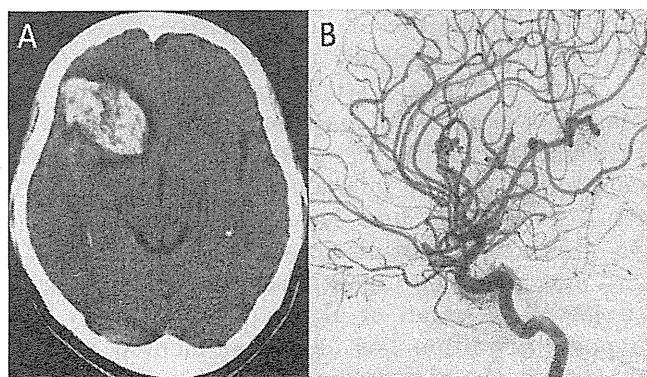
Case 2: A: Computed tomography scan showing a right frontal intraparenchymal hematoma. B: Digital subtraction angiogram showing a grade 1 right frontal arteriovenous malformation.
